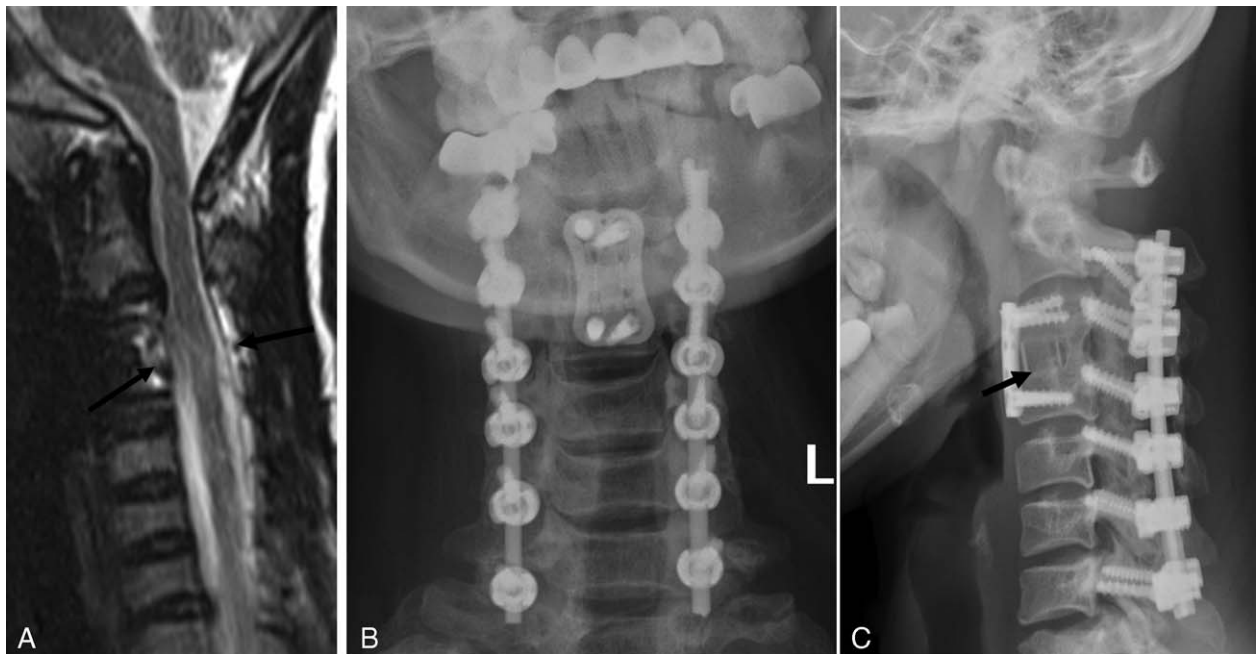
The patient underwent posterior combined and anterior decompression. The magnetic resonance image collected 2 years after the surgery shows no evidence of spinal cord compression (A). Laminoplasty with lateral mass screw fixation at C2–C7 and C3/4 anterior decompression and fusion with a plate and screw system was performed (B). The radiograph obtained 5 years after the operation shows the bone union at the C3/4 vertebrae (C).
